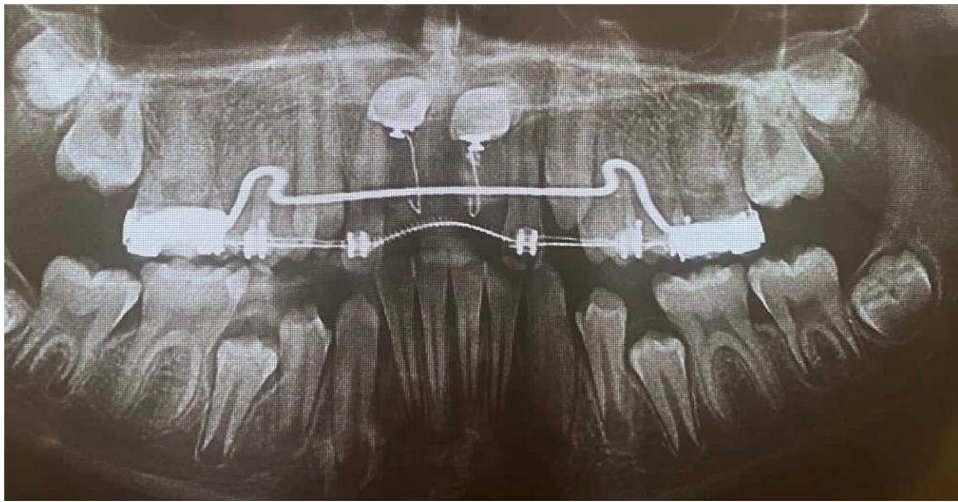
Panoramic radiograph taken one month after the first stage of surgery to evaluate the position of the teeth and attachments.
